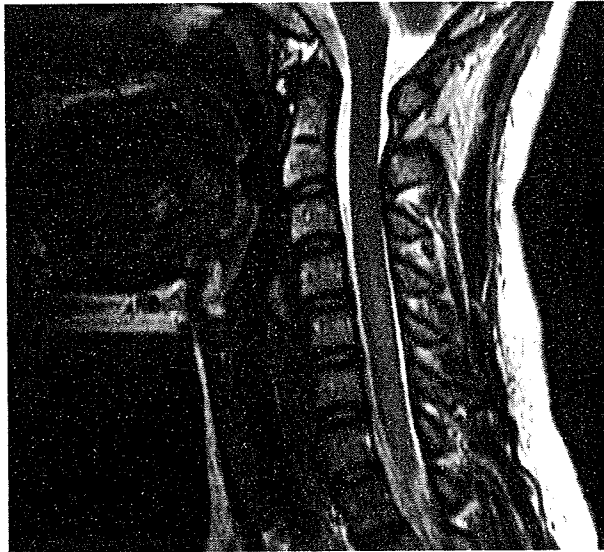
Cervical and thoracic spinal cord MRI (T2-weighted images) at age 27 revealed T2 hyperintense lesion within the central area of cord extending from C6 to T8.
